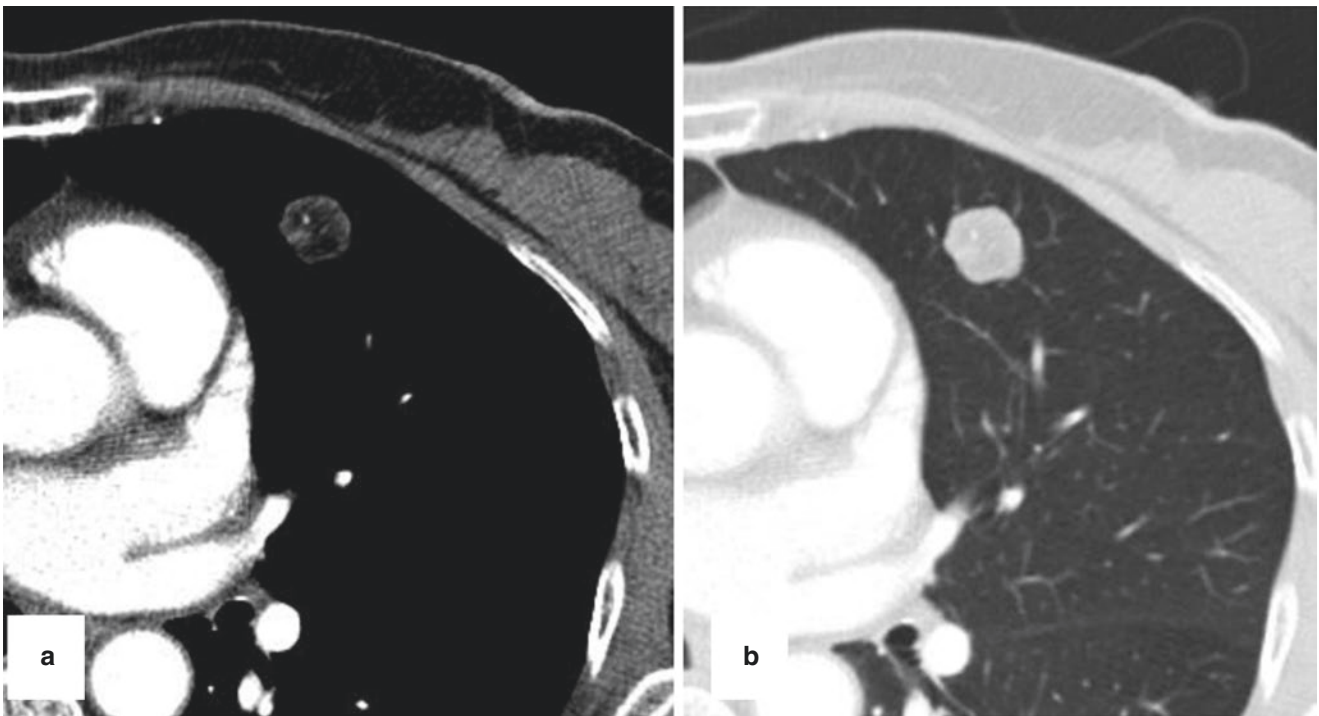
Computed tomography (CT) image showing a 1.7 cm lobulated, smoothly margined fatty nodule with punctate calcification in the anterior left upper lung lobe, consistent with a pulmonary hamartoma
